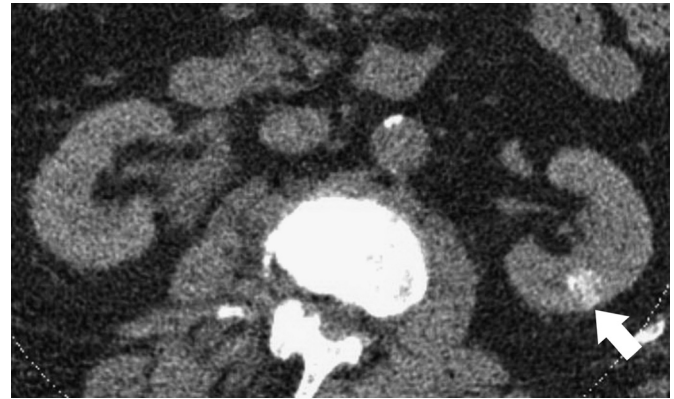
Axial unenhanced CT scan through the kidneys 24 hours after CC in a 72-year-old man shows bilateral faint global nephrograms with a focal nephrogram in the left kidney (arrow). This patient had 2 angioplasties and 2 stents, 240 mL (0.92 g I/kg), of iodixanol 320 requiring 21.7 minutes of fluoroscopy time.
